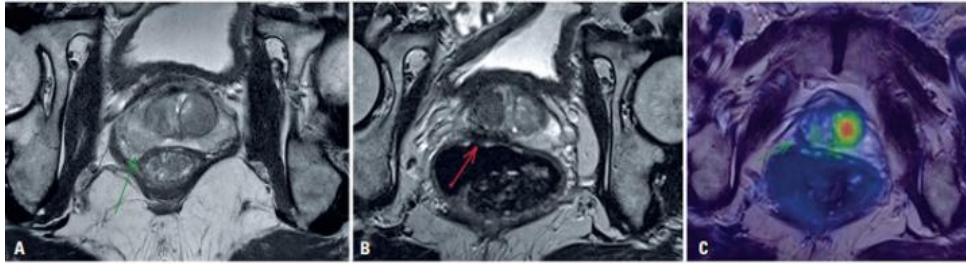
Imaging findings. Magnetic resonance imaging using a T2 weighted sequence shows (A) a slightly hypointense lesion on the right midgland. (B) a markedly hypointense region after treatment on T-2 weighted sequence, and (C) no increased uptake of prostate-specific membrane antigen on PET/CT after treatment.
